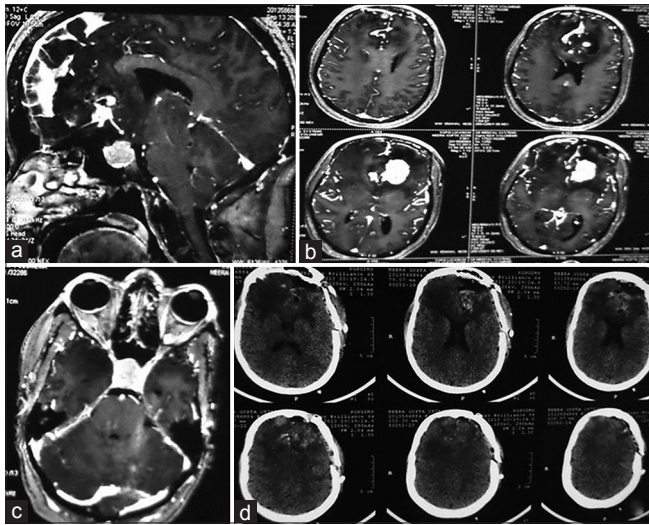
Magnetic resonance imaging contrast showing multiple glioblastoma, involving corpus callosum, frontal as well as sellar region (a-c). Postoperative image (d) showing complete excision of frontal and corpus callosal mass and biopsy taken from sellar mass in same setting
